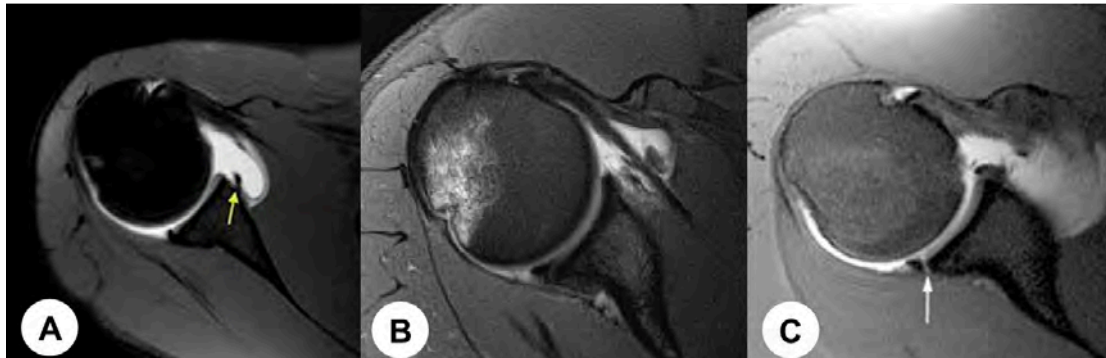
Magnetic resonance images of the associated injuries of shoulder dislocation. (A) Bankart lesion. (B) Hill-Sachs lesion. (C) posterior labral tear (reverse Bankart lesion).
